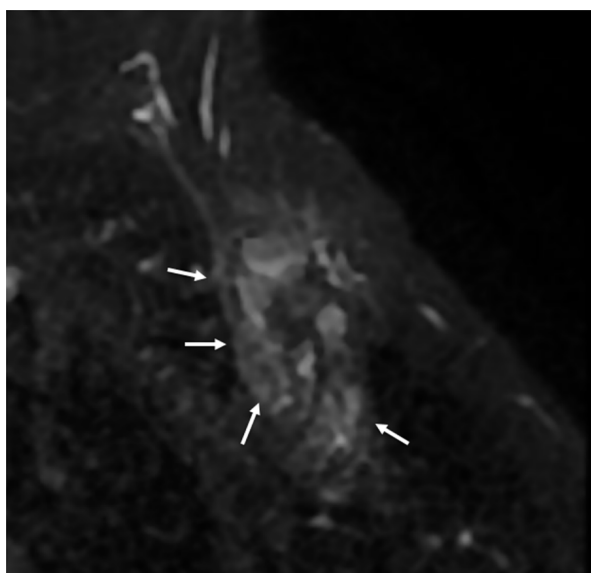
Axial fat-suppressed T2-weighted magnetic resonance image of the axilla in a 65-year-old female patient with invasive ductal carcinoma revealing an increased signal around the metastatic lymph nodes (flare sign) (arrows). Extracapsular extension was detected in five out of eight metastatic lymph nodes as a result of axillary lymph node dissection.
